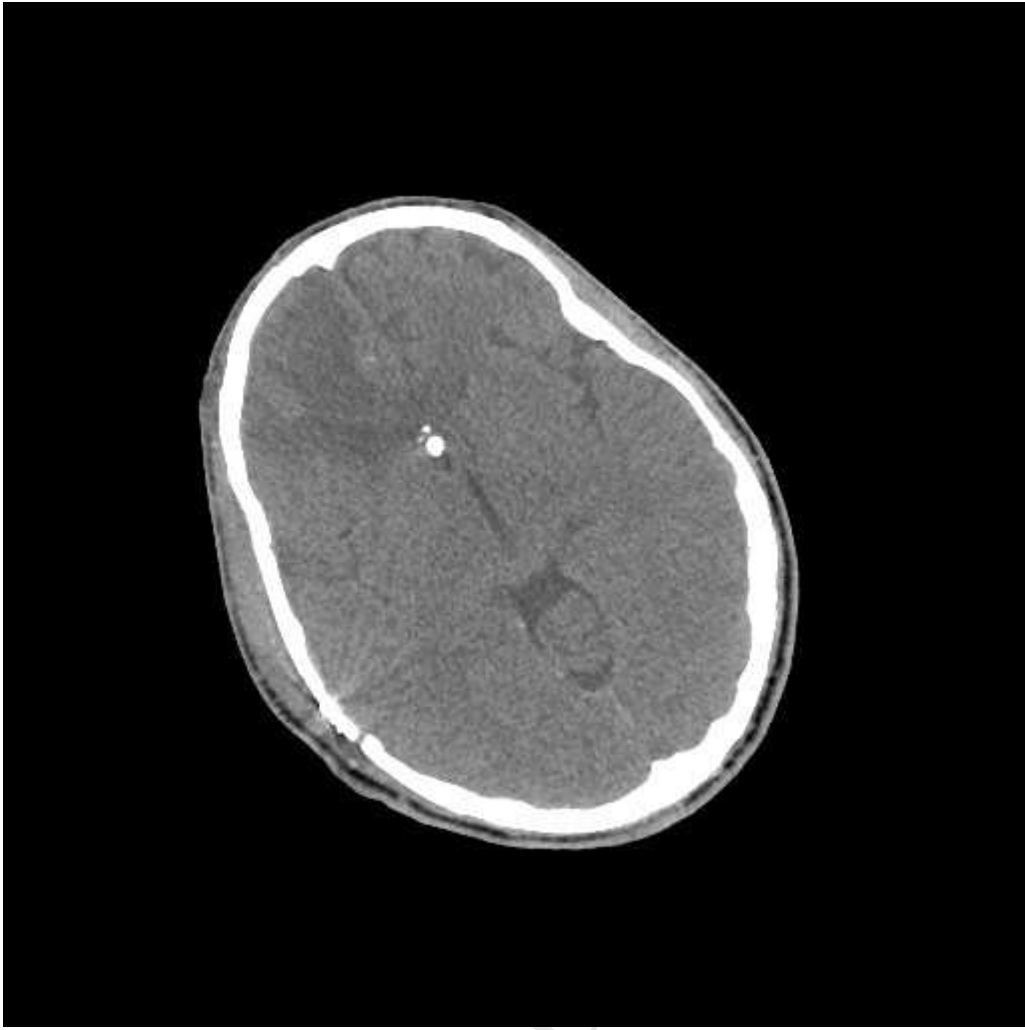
Post-operative CT demonstrating successful removal of the fragment.
